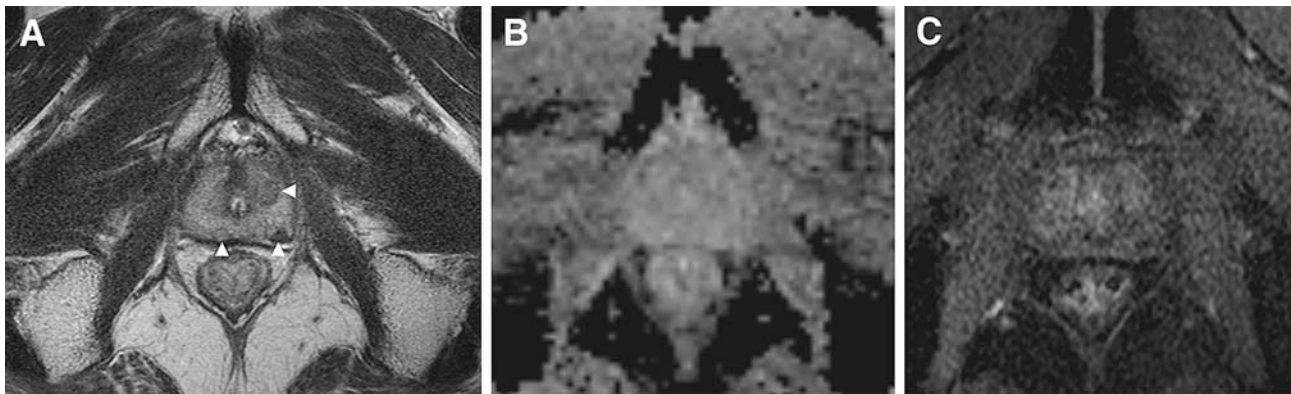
A 67-year-old patient had increased PSA levels 24 months after completion of external beam radiation therapy. A An axial T2-weighted (3368/80) turbo spin-echo image shows three nodular lesions of low signal intensity in both peripheral zones of the midgland (arrowheads), suggesting the possibility of recurrent cancer. B–C However, the axial
